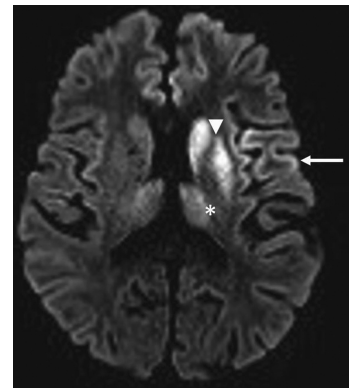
CJD. This b1000 DWI sequence shows diffuse, bilateral thin cortical ribbon of hyperintense signal (*arrow*), more prominent on the left, with additional hyperintense signal of the basal ganglia (*arrowhead*) and thalamus (*) in this male patient (corresponding ADC not shown).
